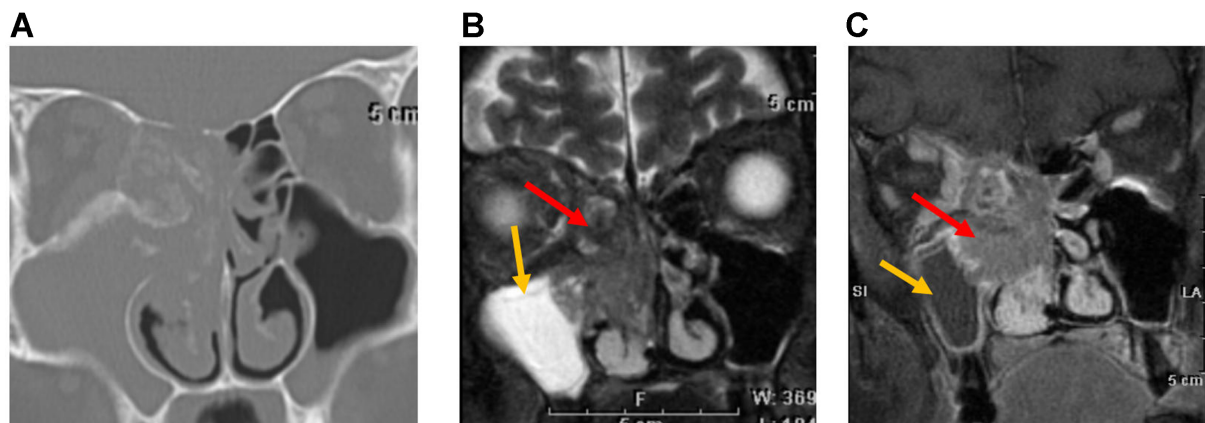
NUT carcinoma. (A) Coronal CT image of the paranasal sinuses in a patient with NUT carcinoma shows a lesion centered in the right nasal cavity with soft-tissue attenuation and aggressive features, including both bone erosion and hyperostosis; (B) Coronal T2-weighted image shows the tumor as isointense relative to gray matter (red arrow). The adjacent maxillary sinus exhibits a hyperintense signal consistent with trapped secretions (yellow arrow); (C) Coronal post-contrast T1-weighted image shows tumor enhancement with a central non-enhancing component reflecting necrosis (red arrow). The right maxillary sinus demonstrates peripheral enhancing mucosa, consistent with an inflammatory process and trapped secretions (yellow arrow). NUT: Nuclear protein of the testis; CT: computed tomography.
